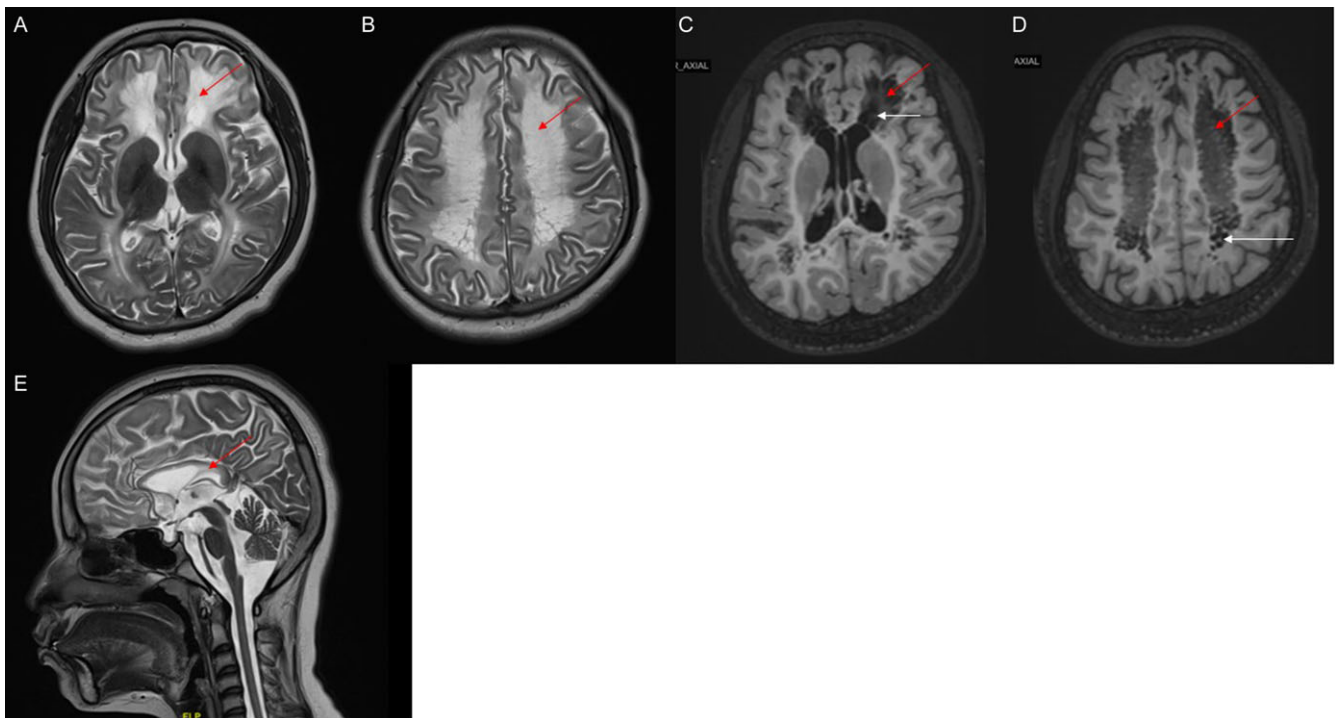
Brain MRI of patient 1. (a) and (b) axial T2-weighted imaging showing diffuse and symmetrical white matter hyperintensities (red arrow); (c) and (d) axial T1-weighted imaging showing symmetrical white matter hypointensities (red arrow) with focal areas of lower signals suggesting rarefaction (white arrow); (e) sagittal T2-weighted image depicts corpus callosum atrophy and hyperintense signal (red arrow). MRI = magnetic resonance imaging.
